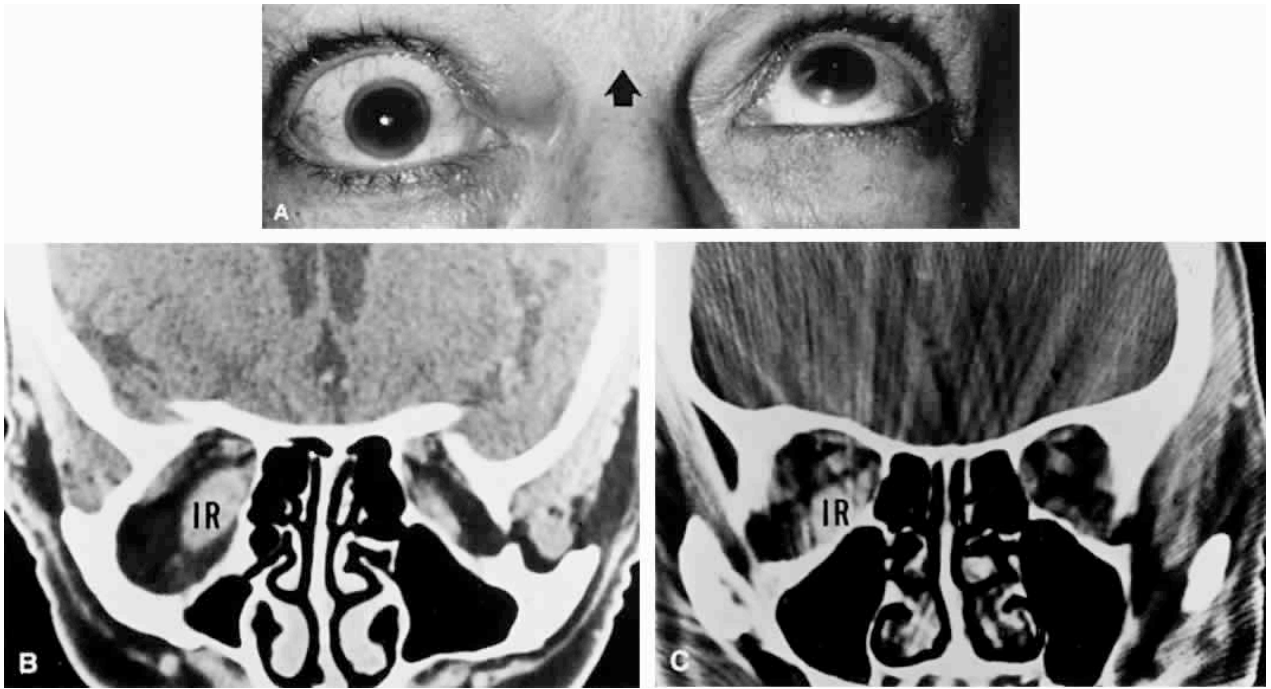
The above images are from a patient with Graves' disease. Note the typical unocular elevator palsy (A) due to enlarge inferior rectus (IR). Off-axial (B) and coronal (C) CT sections showing selective enlargement of right inferior rectus (IR). (Joel S. Glaser and R. Michael Siatkowski, *Infranuclear Disorders of Eye Movement*, Vol 2, Chapter 12, *Neuro-Ophthalmology*, Duane's Clinical Ophthalmology, 2006) (Wiki)
